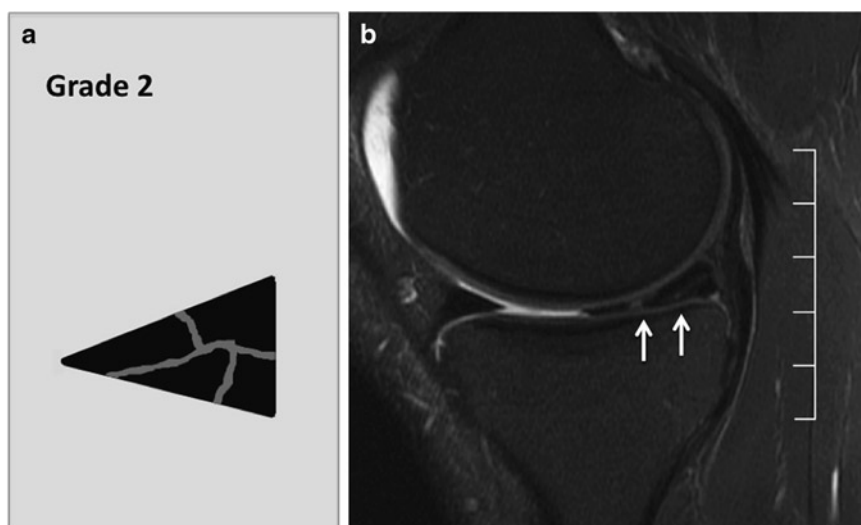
Meniscus with complex tear without deformity, *Whole-Organ-MRI-Score (WORMS) grade 2*. Graph (a) and sagittal fat saturated intermediate weighted fast spin echo sequence of the knee (b) showing a complex, nondisplaced tear of the posterior horn of the medial meniscus that was classified as a grade 2 tear (short arrow). In addition, a parameniscal cyst is demonstrated posterior to the meniscus in direct contact with the meniscal tear (long arrow)
